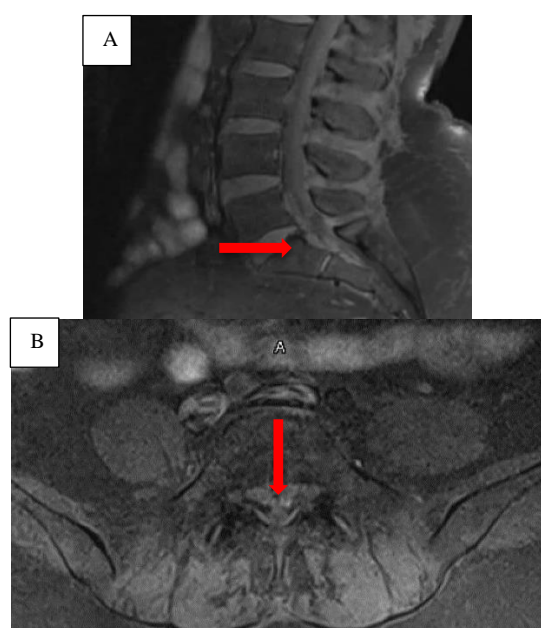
Sagittal (A) and axial (B) cuts of T1 fat-saturated sequence magnetic resonance imaging (MRI) of the lumbosacral spine showing an oval-shaped lesion (red arrow) at the posterior aspect of L5-S1, causing significant lumbar canal stenosis
